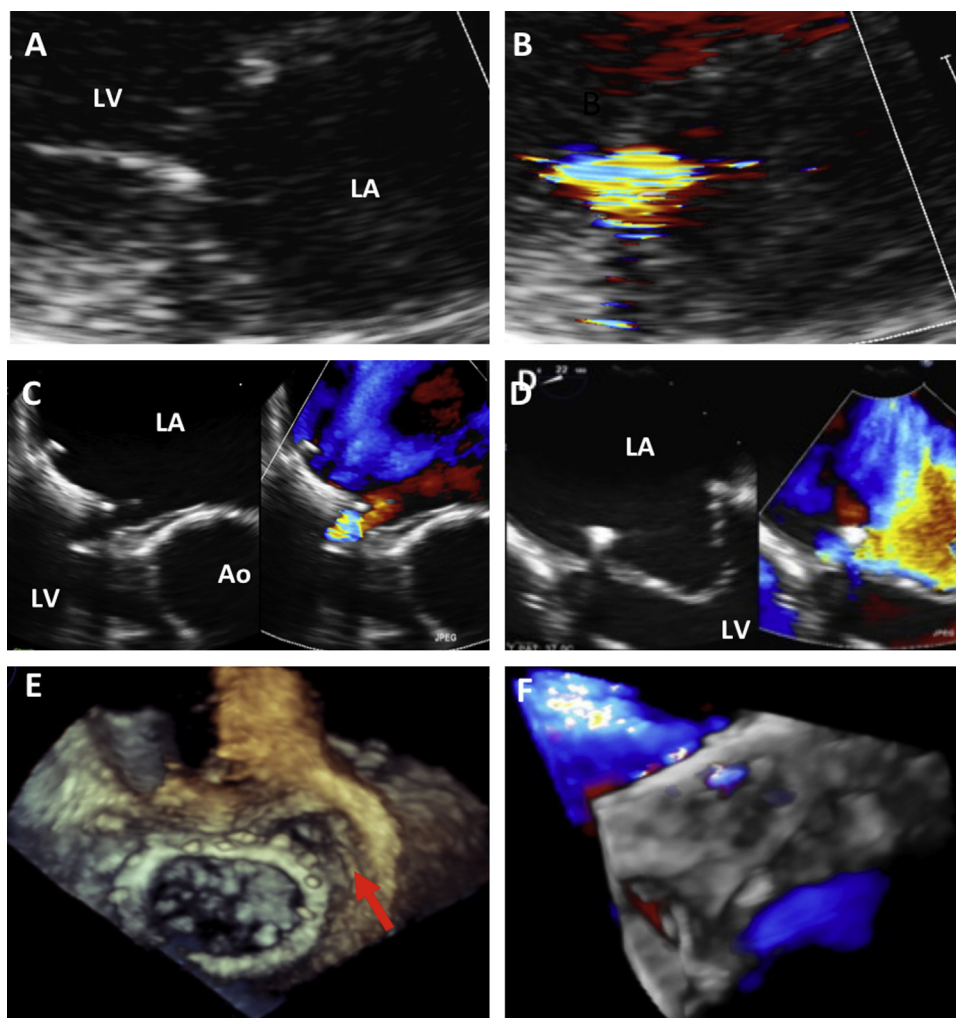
A and B. Two-dimensional transthoracic echocardiography showing mitral regurgitation. C and D. Transoesophageal echocardiography (TOE) showing that the mitral regurgitation is paravalvular with a continent repair. E. Three-dimensional TOE confirms from the left atrial view the tearing tissue area (arrow) on the anterolateral side above the mitral ring and the continent plasty. F. Full-volume colour Doppler image showing the paravalvular mitral regurgitation. Ao: aorta; LA: left atrium; LV: left ventricle.
